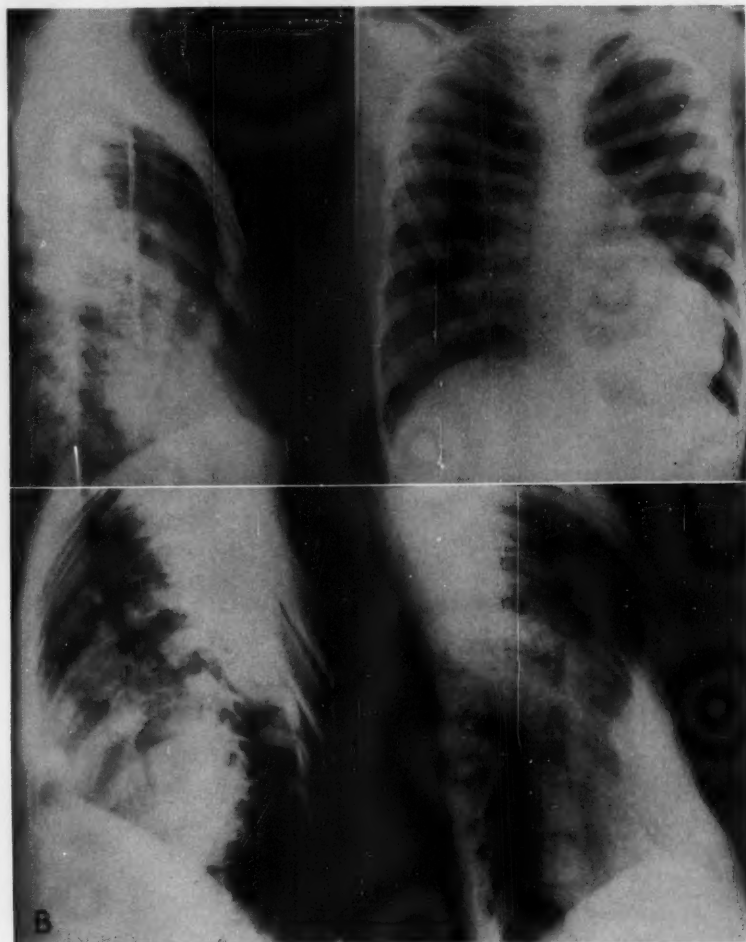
(A) Preoperative roentgenograms on an eleven-year-old boy reveal marked shortening of anteroposterior diameter and displacement of the heart to the left. Note also the marked cephalo-caudal tilt of the ribs as the result of the abnormal length. (B) The left roentgenogram shows the autogenous rib strut in place one month after surgical repair. The lateral roentgenogram on the right demonstrates the large fibrotic mass on the posterior border of the sternum, which again severely shortens the anteroposterior diameter.
